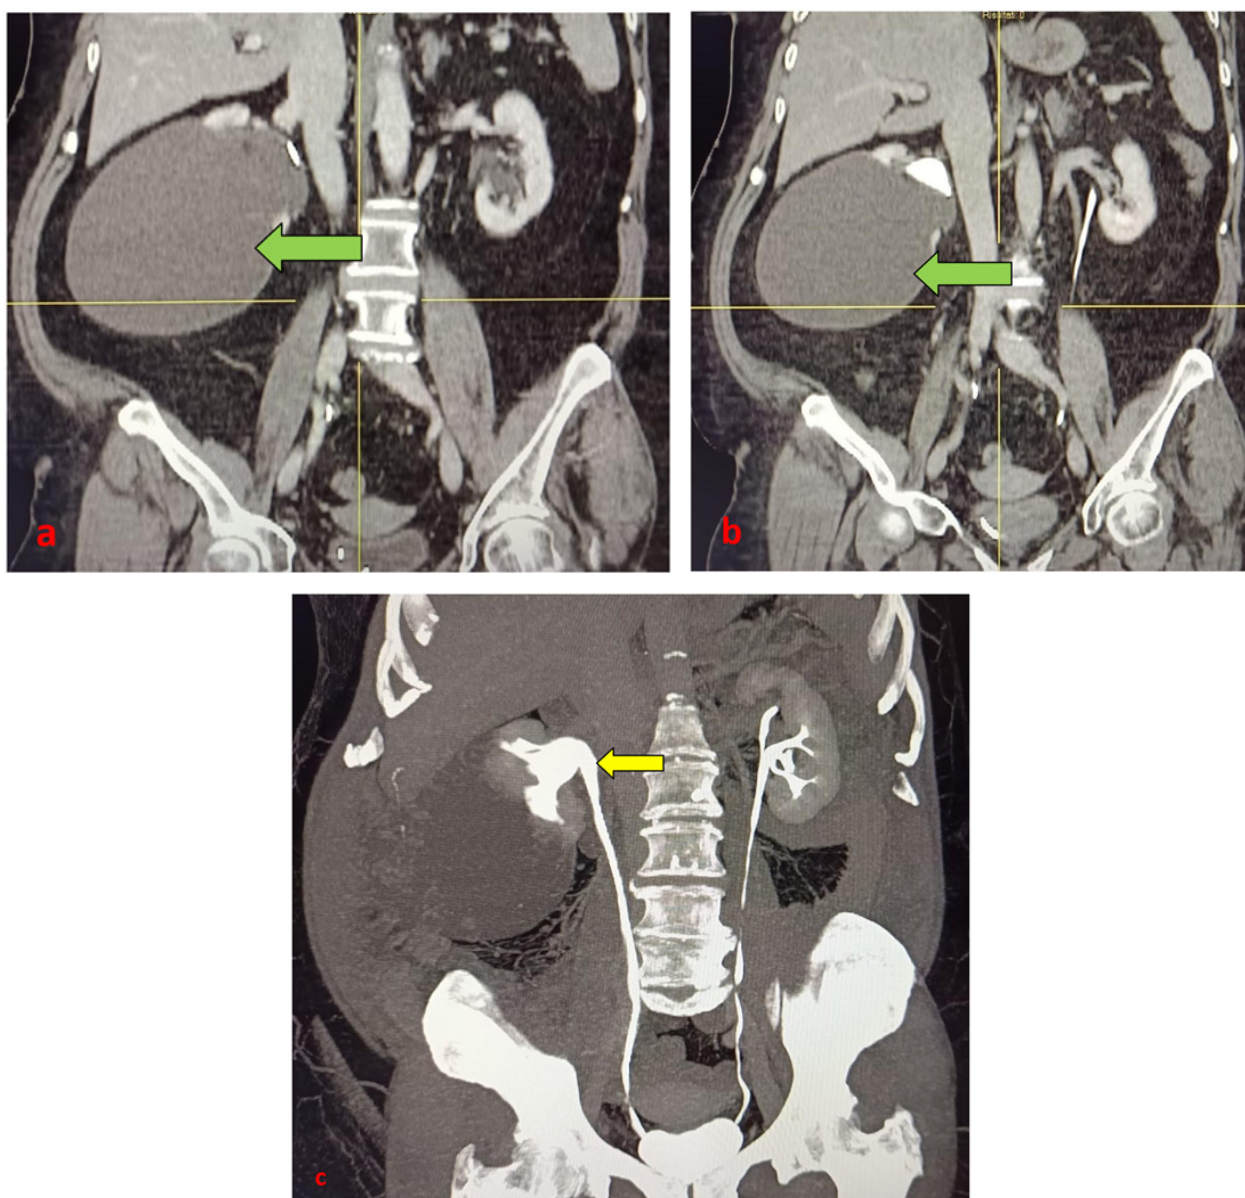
(a-c): CT-urography with Uro-CT scan protocol. CT coronal (a,b) MPR coronal reconstructions, and MIP coronal (c) , had confirmed the presence of a giant renal cyst (13 cms) in the renal cortex of the right kidney (green arrows), with hypodense appearance, exophytic development, without any contrast enhancement in the various phases of the CT study. CT-urography had also shown the presence of a compression on the proximal section of the right ureter, and a consequent dilation of its proximal section, on the right (yellow arrow).
